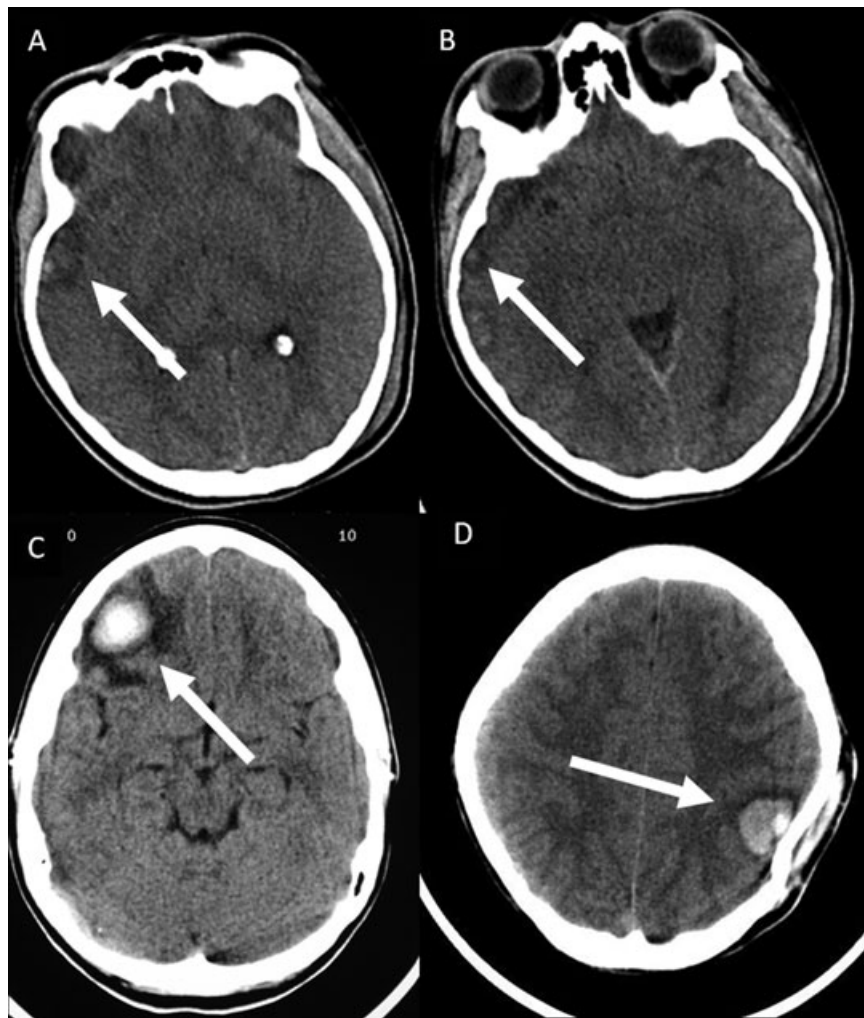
Axial CT images of two pediatric trauma patients with cortical contusions. In patient one (A, B) cortical contusions are seen in both temporal lobes, right > left with only mild subcortical edema. In patient two (C, D), a classical “coup and contrecoup” distribution of cortical lesions is seen. A cortical/subcortical coup is seen underlying a mildly depressed left parietal fracture in combination with a right frontobasal contrecoup lesion.
